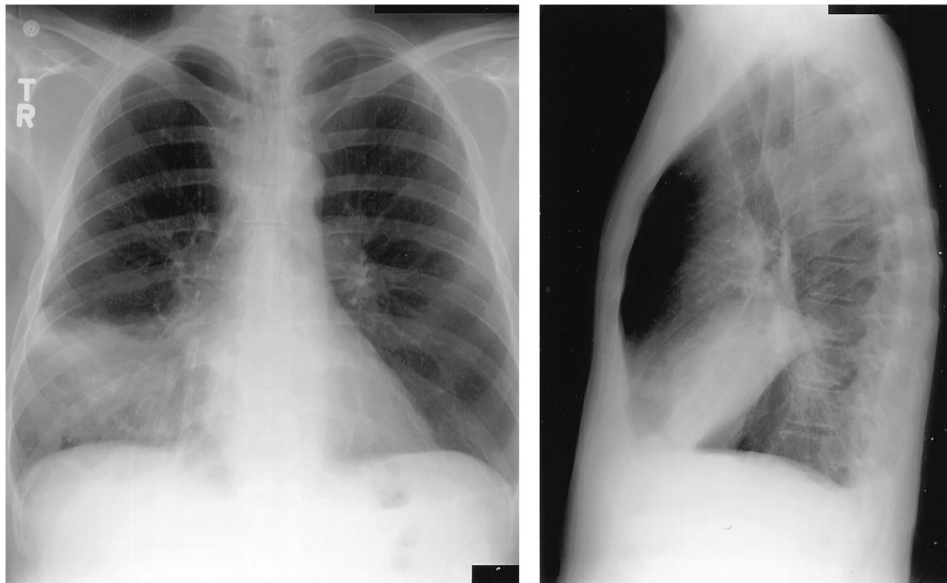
Posteroanterior and lateral chest radiograph from patient 4 demonstrating alveolar hemorrhage presenting as a right middle lobe consolidation.
